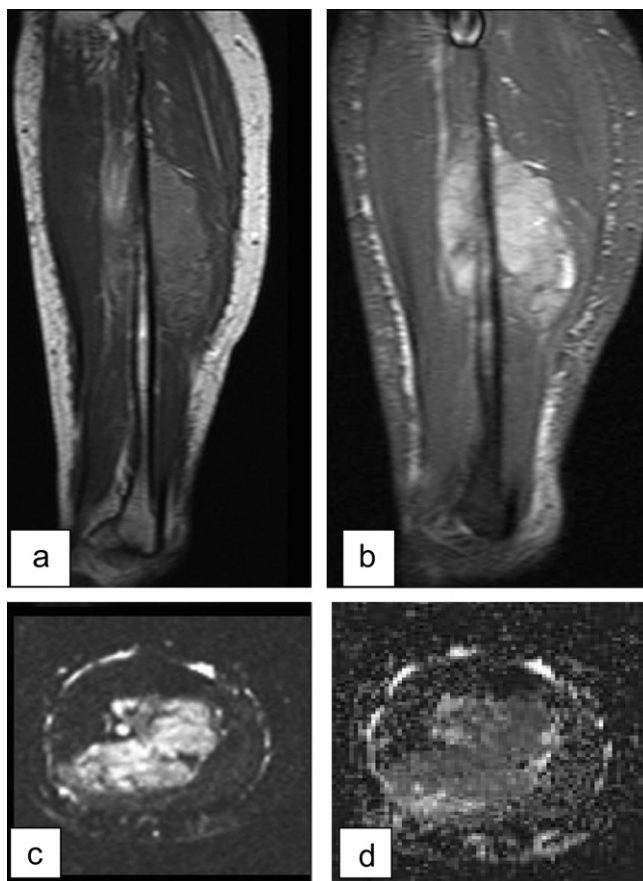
Ewing's sarcoma of the fibula appears of low signal in sagittal T1WIs(a), contrast enhancement in post contrast fat suppression sequence (b). Restriction in DWI(c,d) and ADC. ADC Value 1.1 ± 0.9
